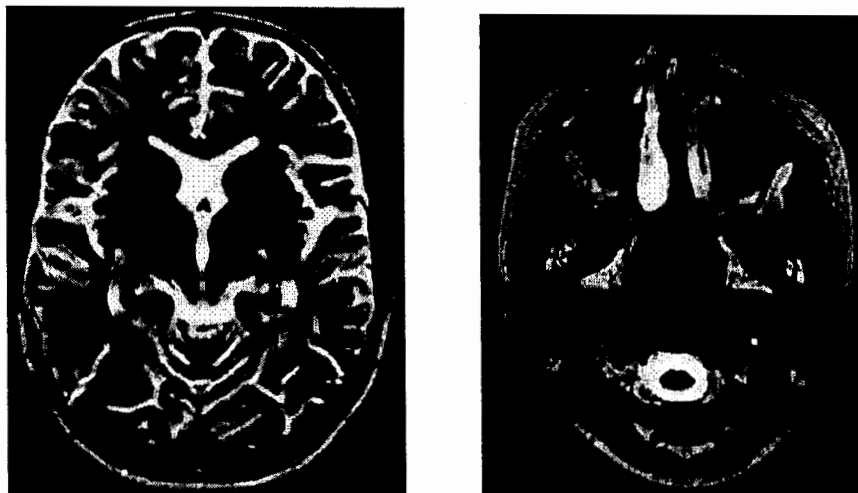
Original Slices of MRI of brain
